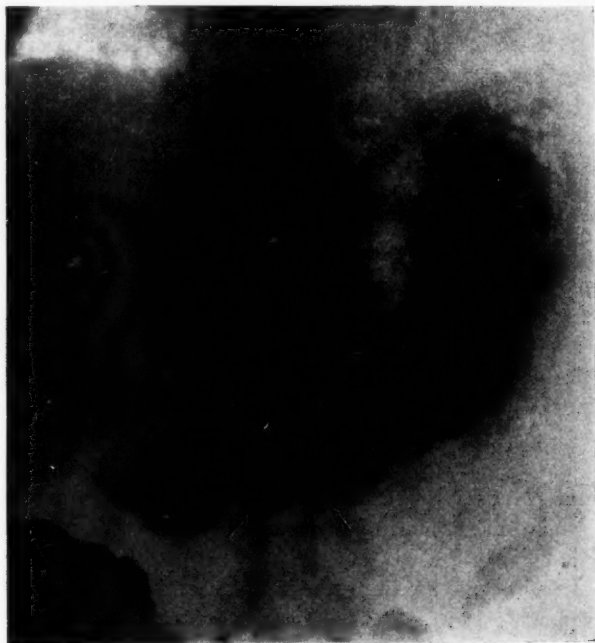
Case I. The picture was made prone and shows the food mass (bezoar) in the distal stomach grasped by the peristalsis. All x-ray observations found the mass in this position and it was also there at operation, but was easily dislodged at the first handling of the stomach.
